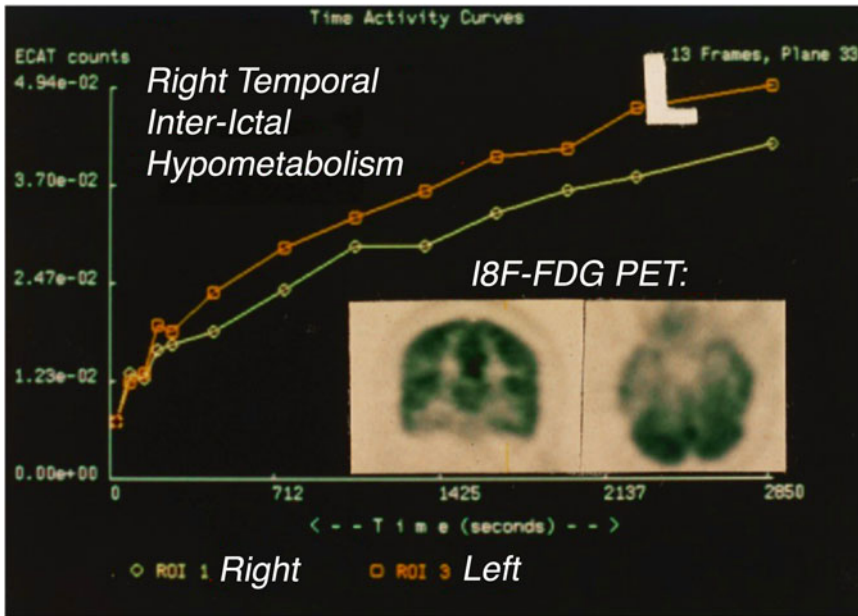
Dynamic PET imaging of 18F-FDG uptake in a complex-partial seizure patient
